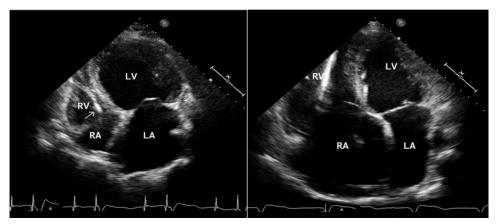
Dilated ChHD cardiomyopathy (stage D). Four-chamber view echocardiograms of two patients with ChHD in congestive HF with severe global hypokinesis and low ejection fraction, similar to other dilated cardiomyopathies. A pacemaker wire is seen in the right heart chambers (*arrow*). (*Left*) The left ventricle (LV) and left atrium (LA) are severely dilated with normal size right ventricle (RV). (*Right*) Biventricular and biatrial severe dilatation. *RA*, Right atrium.
